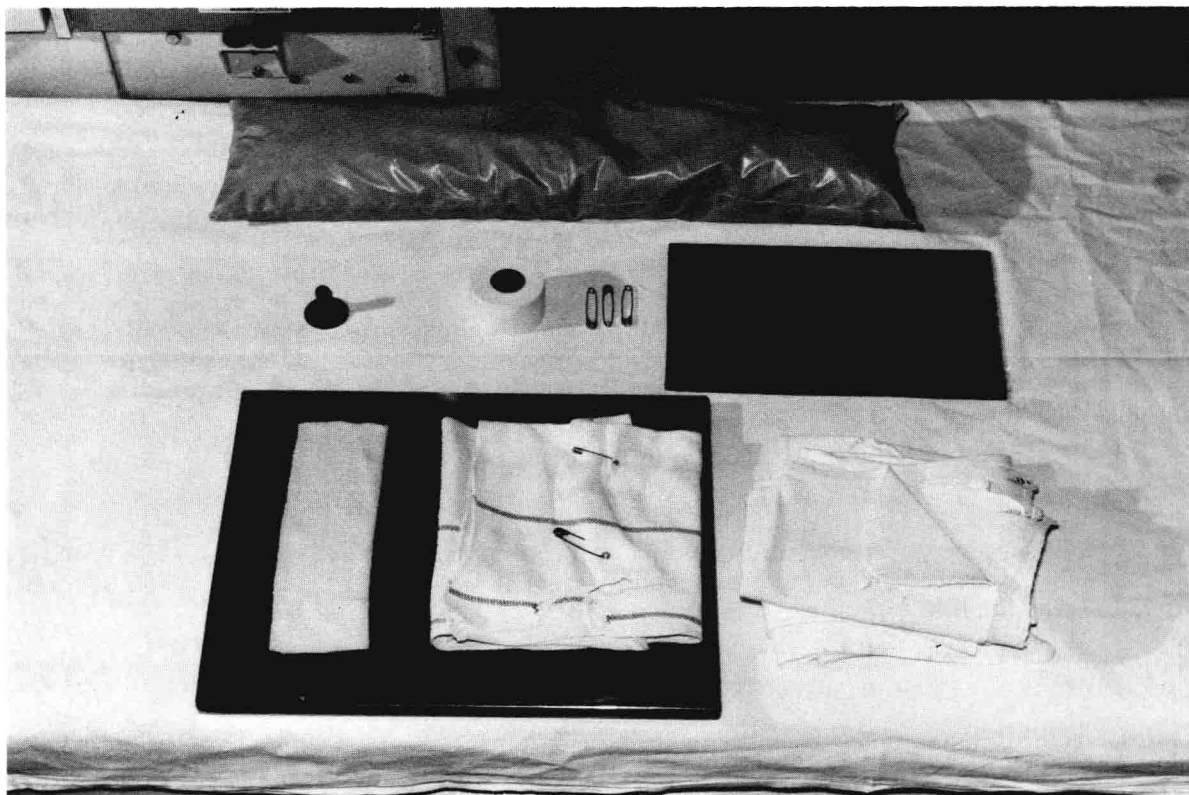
EQUIPMENT USED IN PEDIATRIC X-RAY TECHNIQUE
